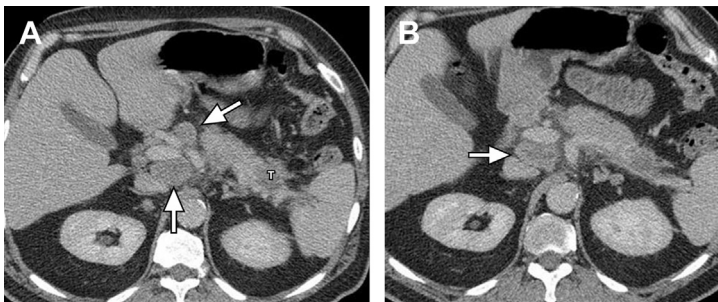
Metastatic pancreatic adenocarcinoma to lymph nodes outside the operative field. (A, B) Axial contrast-enhanced multidetector computed tomography (MDCT) images in the portal venous phase demonstrates a hypodense lesion (T) in the pancreatic tail consistent with pancreatic adenocarcinoma. Enlarged porta hepatis and portocaval lymph nodes are seen (arrows). The primary pancreatic would have been classified as resectable, but the presence of the metastatic lymph nodes outside the operative field (distal pancreatectomy) changes the classification to metastatic disease.
